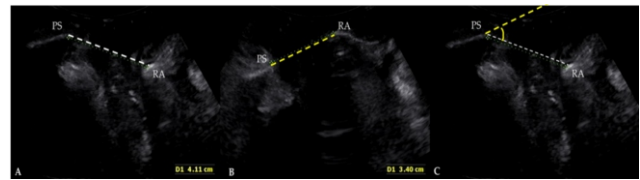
Translabial ultrasonography in patients with pelvic organ prolapse (POP) at rest (A), and in the maximal Valsalva phase (B). PS: pubis symphysis; RA: rectal ampulla. Angle measured between a reference line through the inferior margin of the symphysis pubis and the levator plate connected to the rectal ampulla, at rest (white dotted line) and during the Valsalva maneuver (yellow dotted line) (C).
